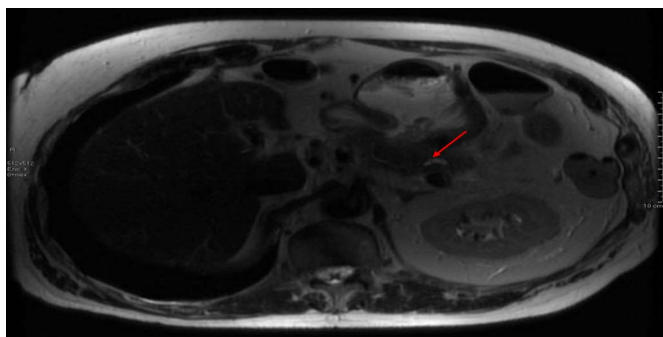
Magnetic resonance imaging showing the small fistulous tract (red arrow) connecting gastric body and the pancreatic tail in our patient.
